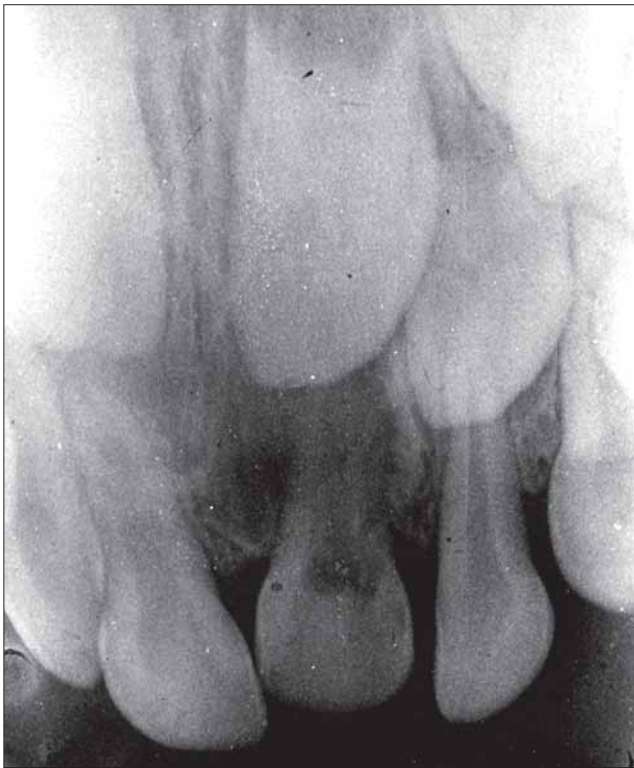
Case 1. Periapical radiograph post surgery.
